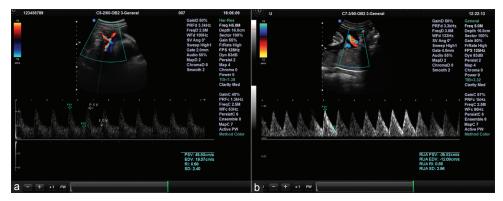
(a and b) Color and duplex Doppler ultrasound demonstrating the uterine waveform (a) and the characteristic saw tooth appearance of the umbilical artery (b) with the peak systolic velocity and the end-diastolic velocity demonstrated
